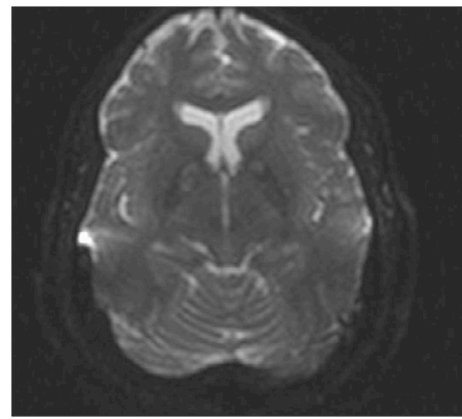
Bilateral globus pallidus ischemic injury in diffusion-weighted images of MRI.
